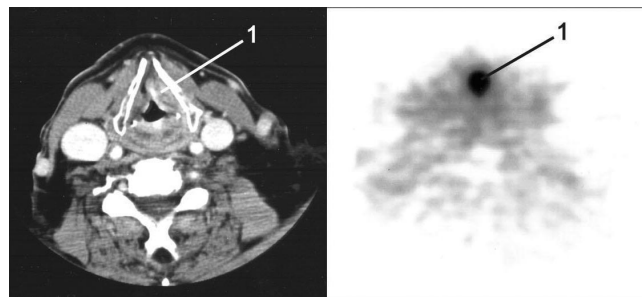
Transaxial CT and ^{11}C -TYR PET scans of patient 28, with T3 N0 supraglottic squamous cell carcinoma (1), show increased ^{11}C -TYR uptake in tumor.
